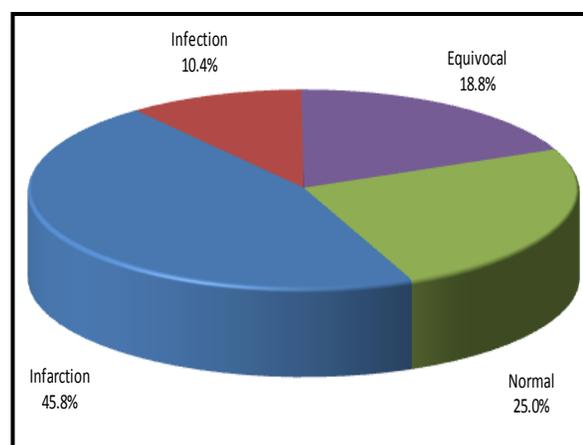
Pie charts for MRI diagnosis of the studied sickle cell anemia patients
